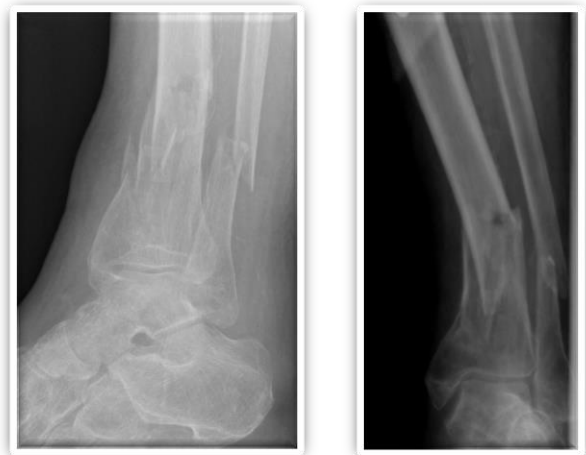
65 year-old female sustain a low impact fall on uneven ground and fracture the distal tibia with extension to the joint as well as the distal fibula. The foot was laterally displaced in relationship to the proximal leg. CT scans show medial comminution and intra-articular fragmentation. The patient was placed in a Delta frame for 2 weeks until the edema was reduced and the soft tissue was optimal for ORIF.
